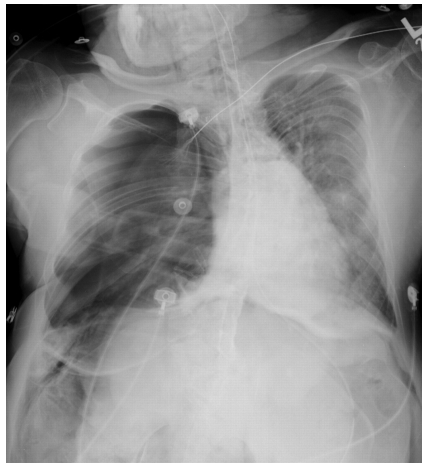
X-ray of a patient presenting kyphoscoliosis.
